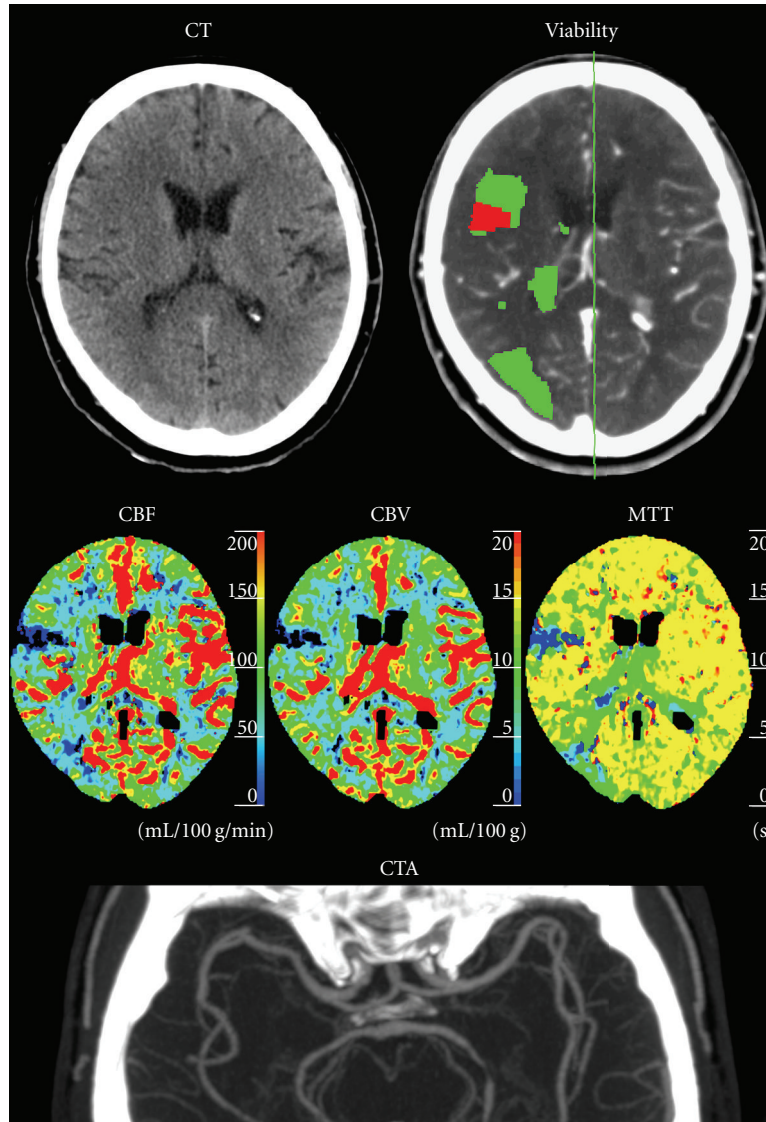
Case 2: 65-year-old male left-sided stroke symptoms and a normal NECT. The CTP viability map shows multiple perfusion defects (green) and a small area of advanced perfusion deficit (red) in the right hemisphere consistent with fragmented cardiogenic embolism. The CTA showed no major arterial occlusion obviating neurointervention.
